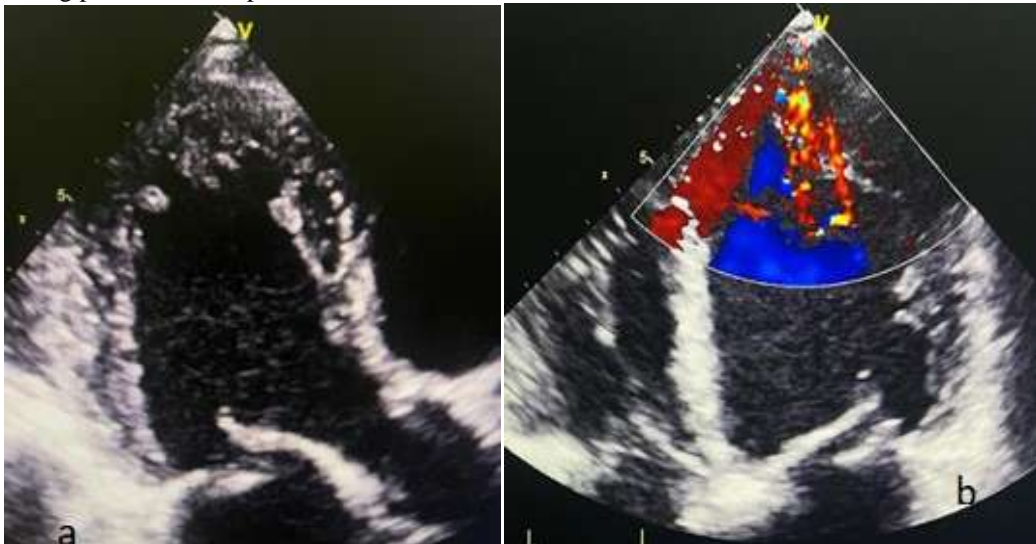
(a) Apical 3 chamber view showing the P2 prolapse with prominent ventricular trabeculations, (b) Apical 4 chamber view showing the deep intertrabecular recesses.
